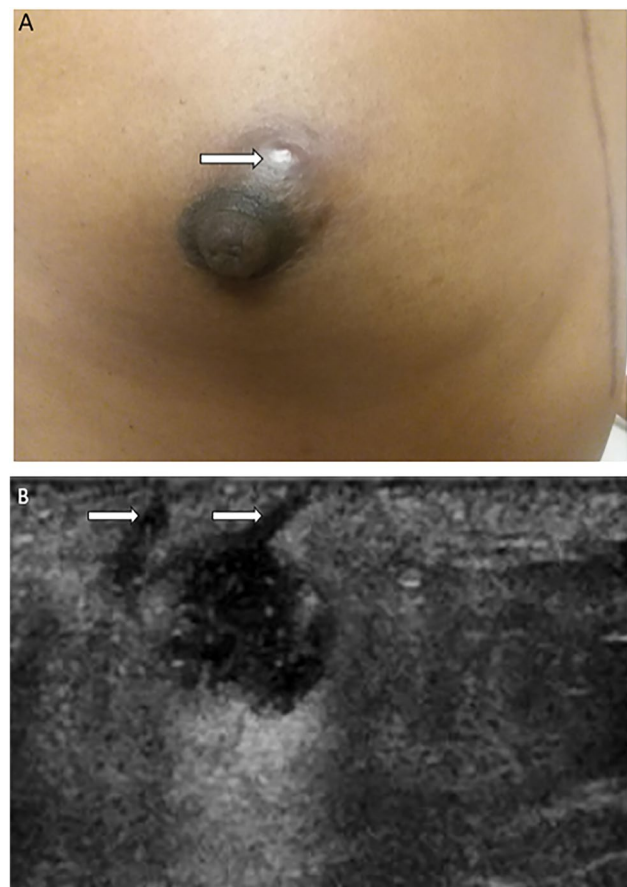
A. A 45-year-old woman presents with a left breast areolar margin breast mass that contains a central punctum on visual inspection (arrow). B. Ultrasound demonstrates a 1.2-cm superficial mass with two sonographically-evident skin tracts (arrows). Findings are consistent with epidermal inclusion cyst
